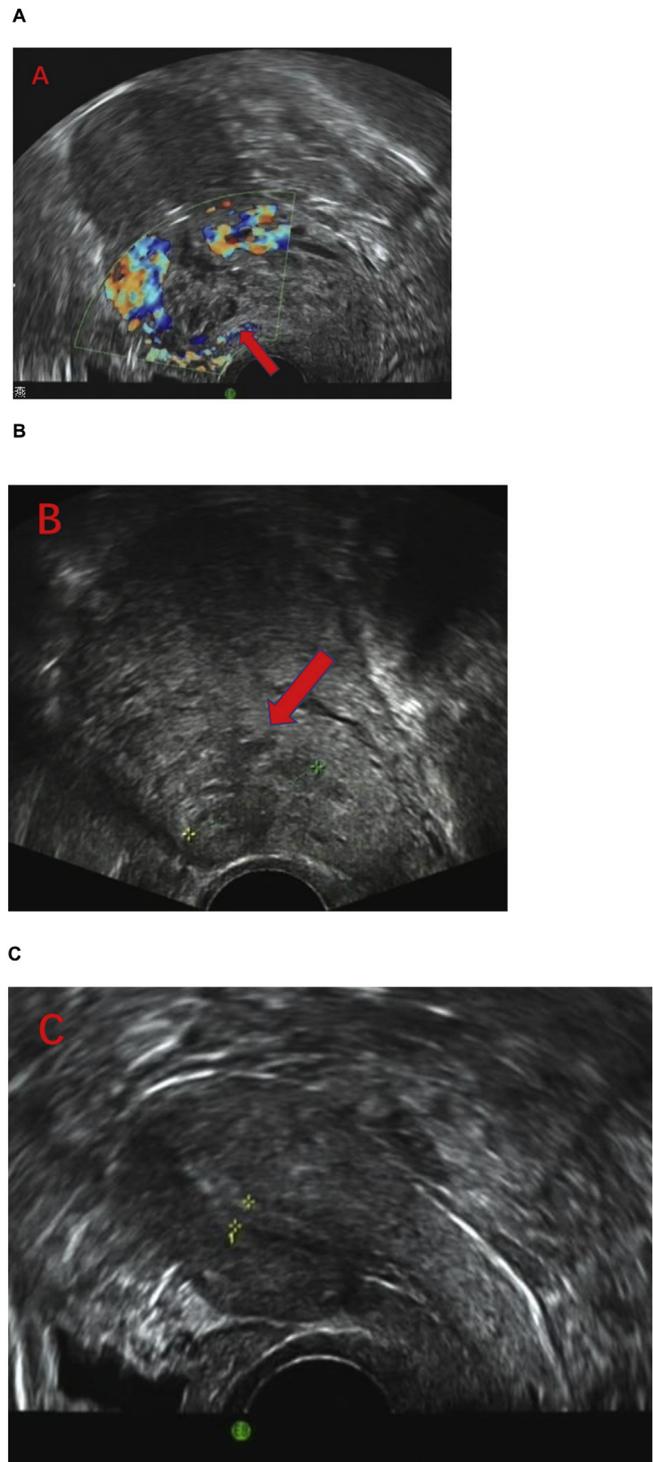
A 38-year-old patient, 2 years after cesarean section. She had been amenorrheic for 5 weeks, with a blood β HCG level of 578 U/L. Ultrasound showed mass scar pregnancy after complete curettage of uterine cavity. (A) A mass was found by ultrasound, Methotrexate (50 mg) was dissolved in 1.0 ml water and injected into the lesion site with rich blood supply; (B) the mass size markedly decreased 3 weeks after treatment; and (C) the mass at the scar region disappeared 4 weeks after treatment.
